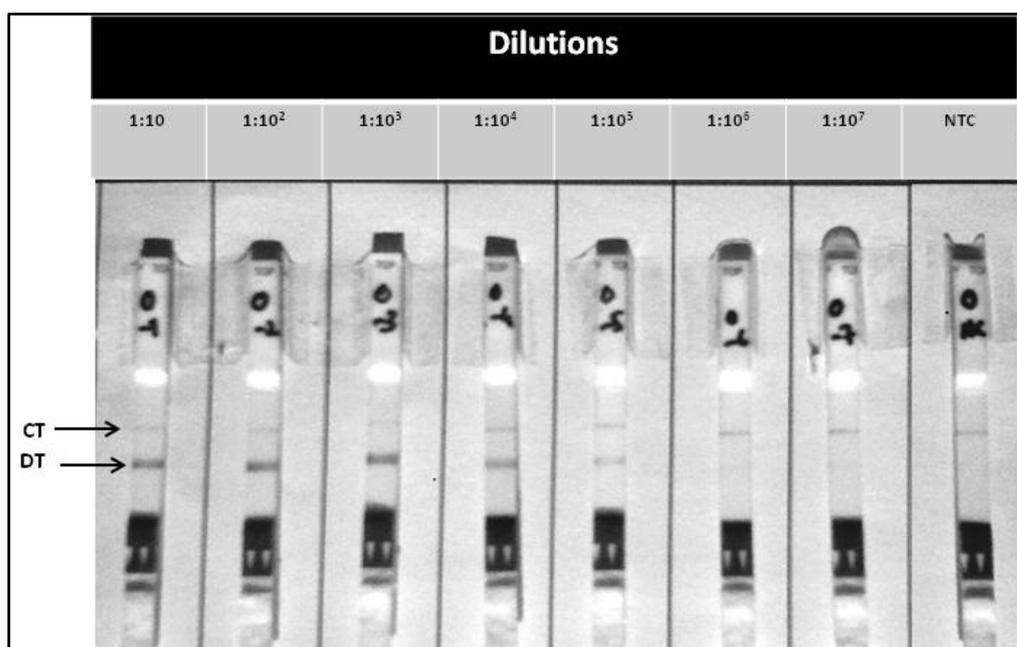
Figure C-2. Sensitivity of one-step LFS-RPA assay for detection of the 10-fold serial dilution of YFV RNA. CT: control line, DT: detection line.
